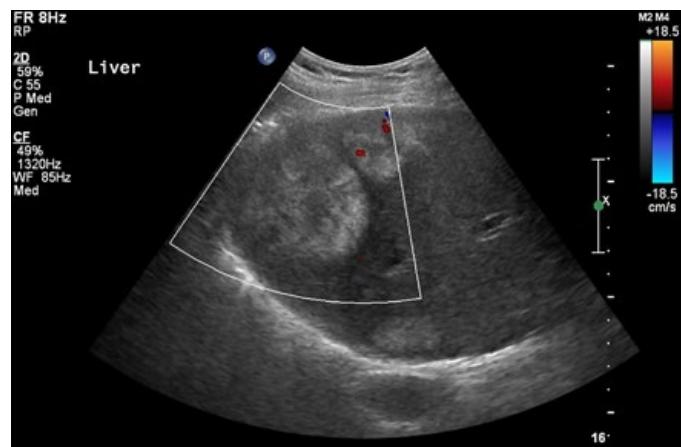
Ultrasound image of the liver showing multiple variable sizes of hyperechoic to hypoechoic heterogeneous masses in the liver showing no abnormal vascularity.
